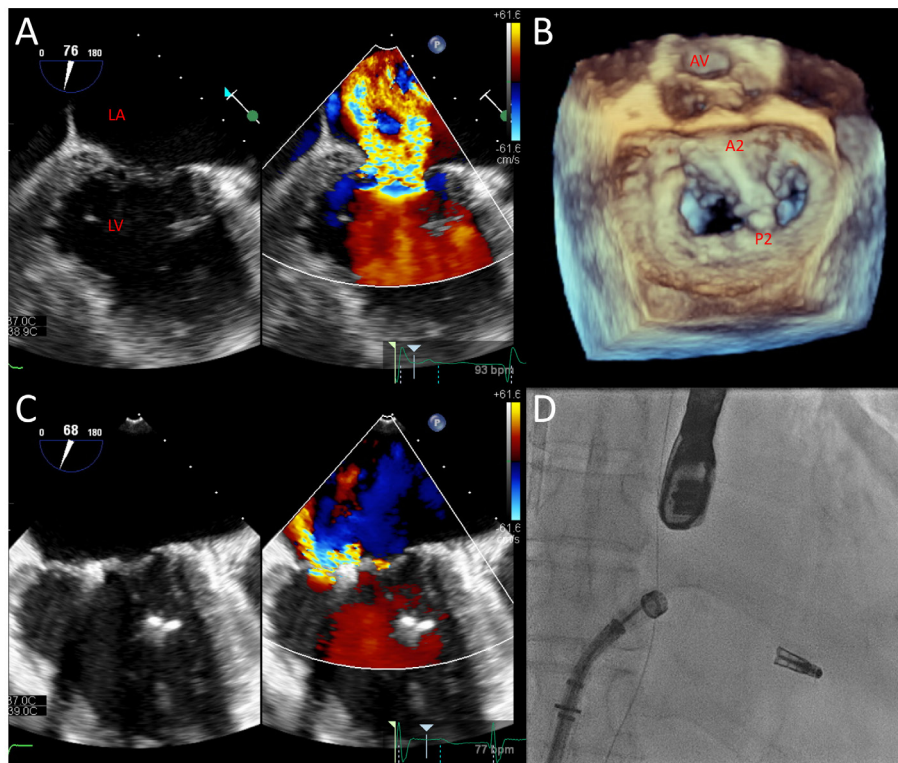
A: Preprocedural transoesophageal echocardiogram in the intercommissural view shows 4+ functional mitral regurgitation with a central jet. B: Three-dimensional view of the mitral valve (surgical view from left atrium) shows deployment of single MitraClip to the A2/P2 segment. C: Reduction of overall mitral regurgitation grade to 2+. D: Fluoroscopic view of deployed MitraClip. AV: Aortic valve; LA: Left atrium; LV: Left ventricle
